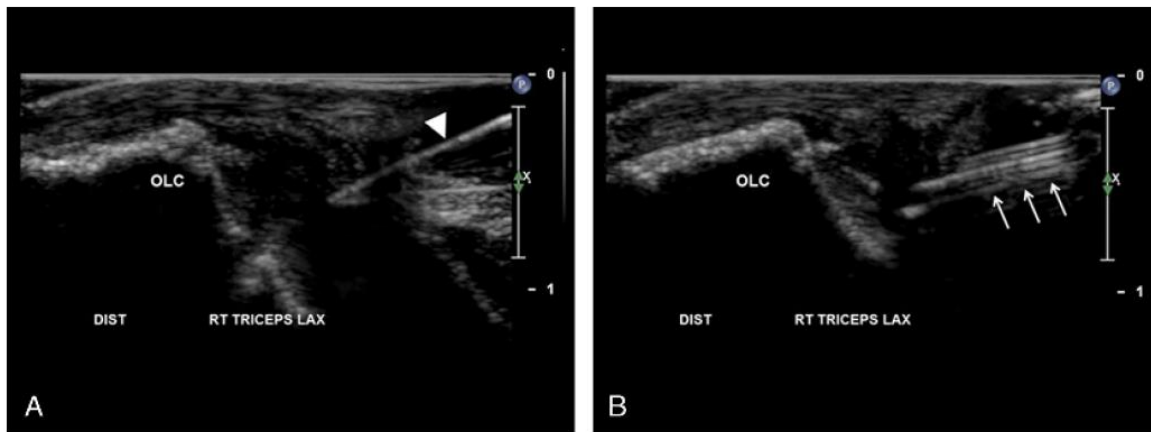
A companion case of triceps tendinosis treated with ultrasonic percutaneous tenotomy. (A) After obtaining local anesthesia, a no. 11 blade (arrowhead) is used to create a tract down to the tendon. (B) The TX1 device (arrows) is then directed to the pathologic regions within the tendon and ultrasonic debridement performed. DIST, distal; OLC, olecranon.
